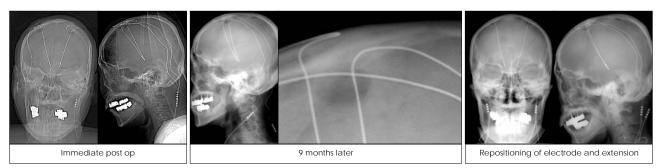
A 79-year-old woman with 6 years history of PD underwent Gpi DBS. We checked X-ray immediately after operation. 9 months later, she complained resting tremor and bradykinesia. Dislocation of electrode was found. Reposition of electrode and extension was done.
